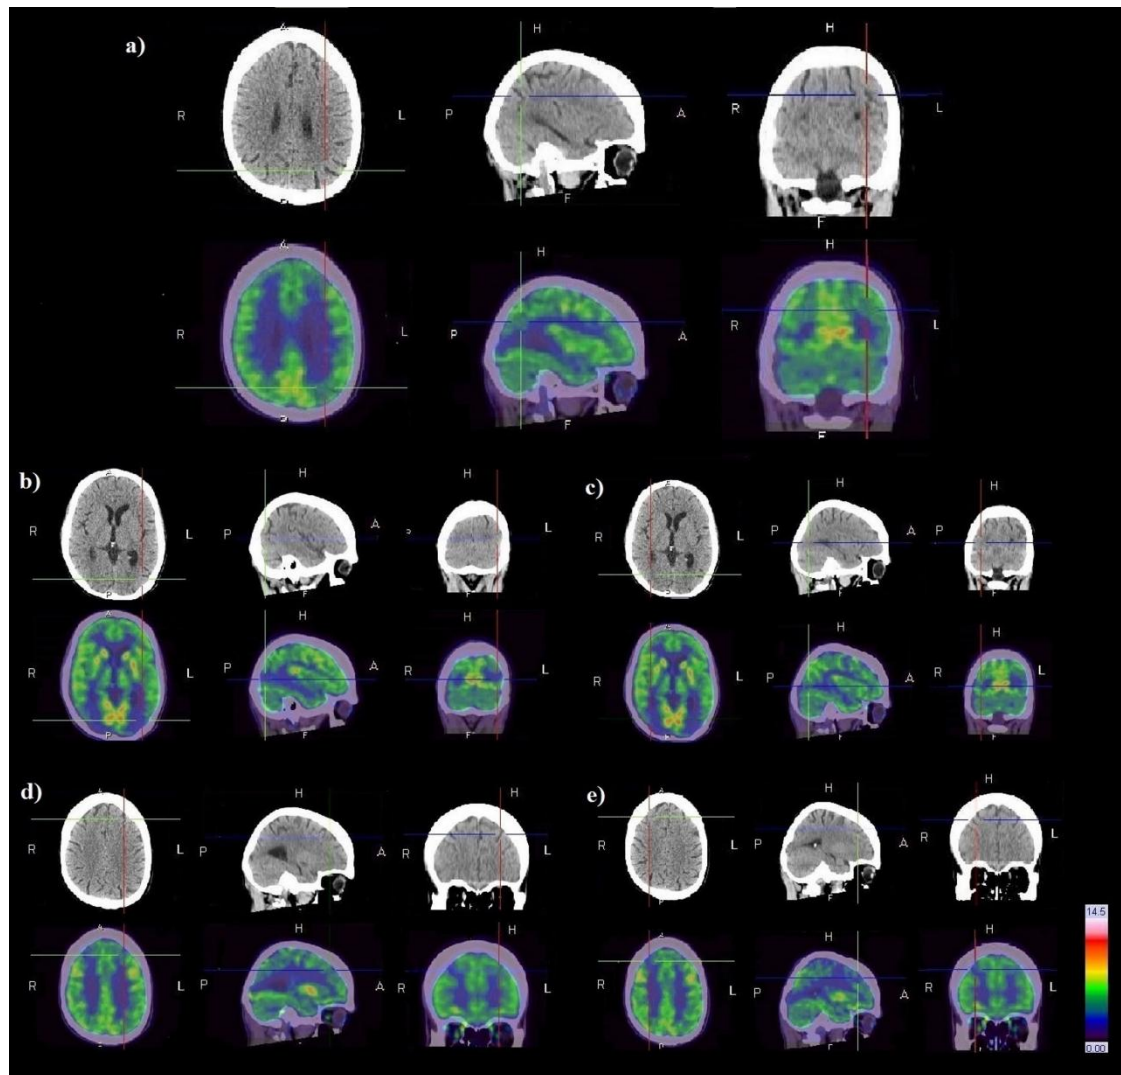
(18)F-FDG Brain PET/CT. The patient was asked to fast for at least 6 hours before the examination. The blood glucose level of the patient was determined before the examination. Scanning was not performed until the blood glucose level was less than 140 mg/dL. The test was performed using a hybrid PET/CT scanner (Siemens mCT Biograph, Germany). The Brain CT scanning was performed using a continuous spiral technique on a 64-slice helical CT, and the PET scanner had three detector rings. No contrast medium was administered during CT scanning. After the CT scan, an emission scan was performed from the head to the thigh after the intravenous injection of 0.08 mC/kg (2.96 MBq/kg) FDG. CT and PET scan data were co-registered. The standardised uptake value (SUV) was acquired using the attenuation-corrected images, the amount of injected FDG, the body weight of the patient, and the cross-calibration factors between PET and the dose calibrator. The images are displayed following the neurological standard (left to right side) and are based on an SUV scale (from red = activation to blue = no activation). Reduced metabolism is evident in: a) temporo-parietal areas, b) left and c) right parietal-occipital junctions; d) left and e) right frontal areas.
